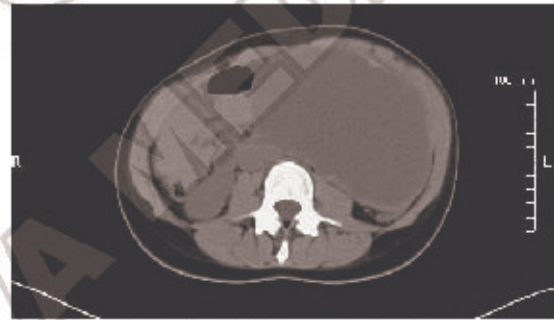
Abdominal CT showed voluminous not subdivided pancreatic cyst with hyperdense and calcified walls, likely to be congenital nature (circle); cystic lesion sized 11x11x17 cm.
